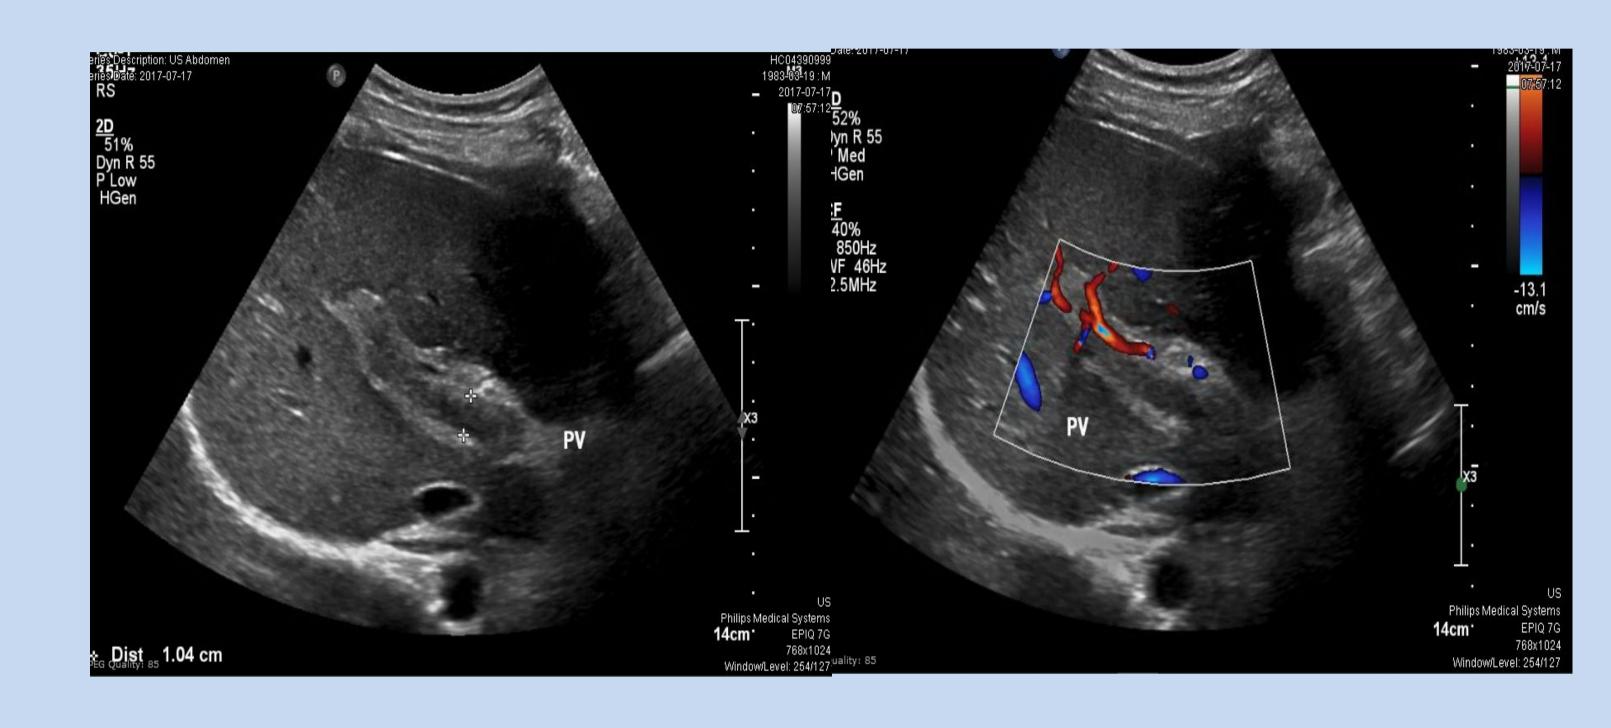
APVT in abdominal US and no doppler signal on the PV
